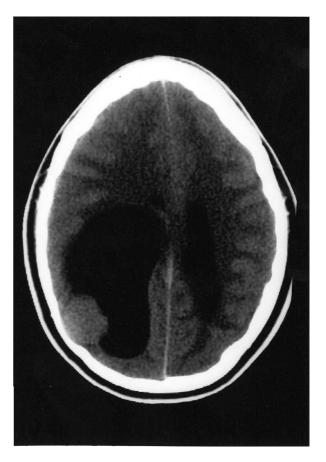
A 2.5-cm temporo-occipital tumor isodense to the cortex on CT with a large cyst and remodeling of the inner table of the calvarium.
